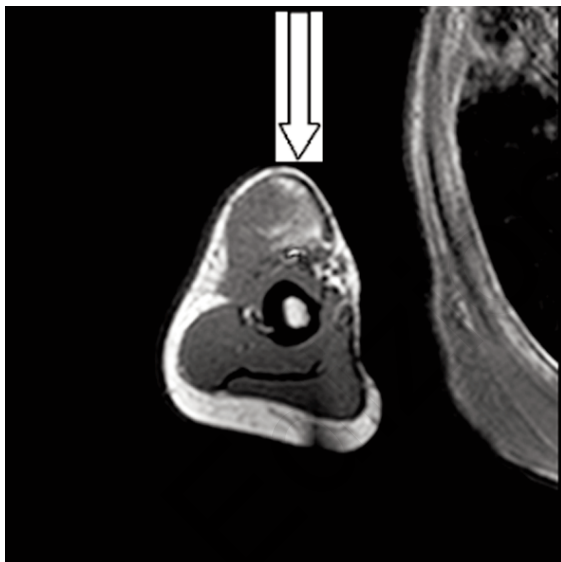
T1 axial coronal magnetic resonance image showing biceps brachii tear and hematoma.
